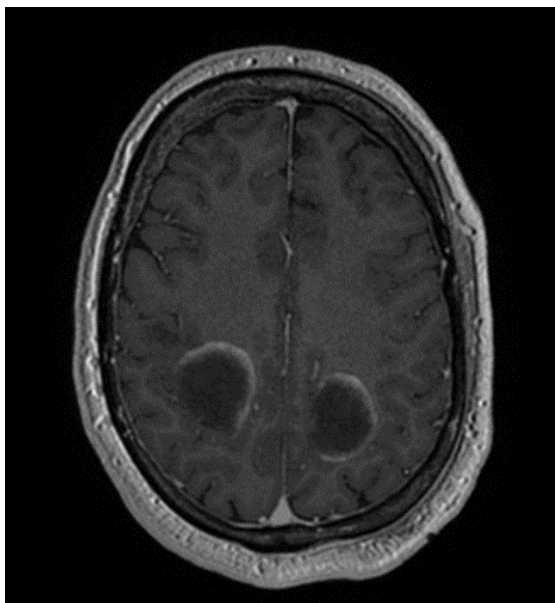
MRI images in T1 post contrast taken prior to treatment
